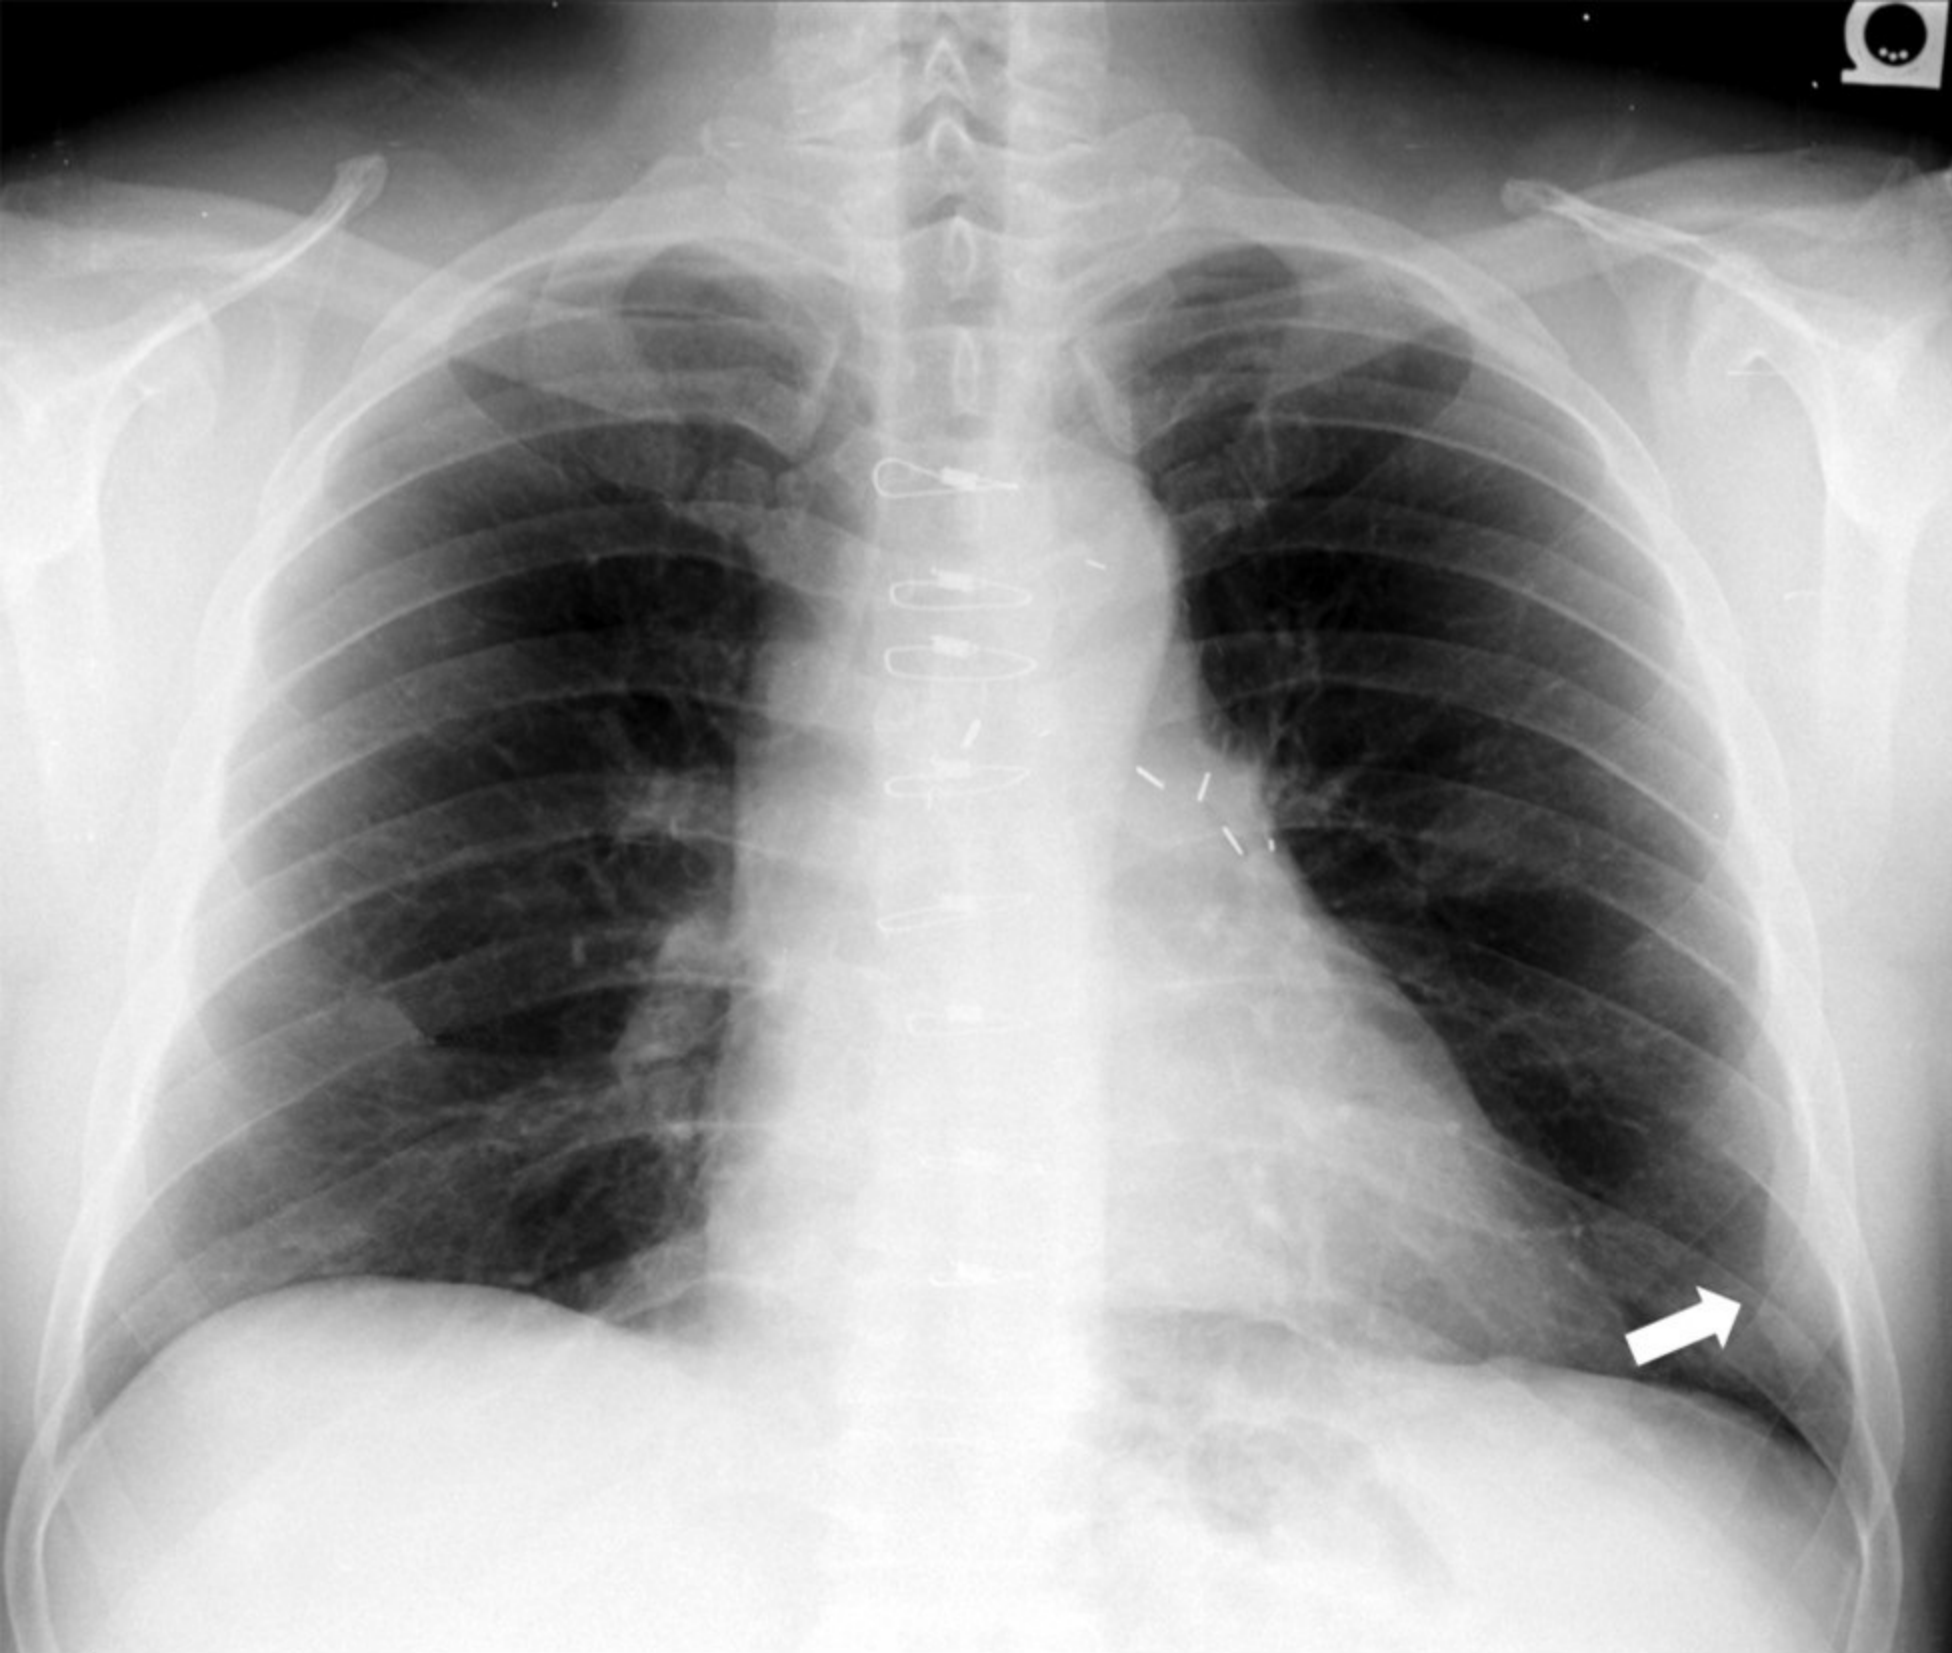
Demonstrates pleural thickening at the left base on chest radiograph (white arrow); CT image showing pleural plaque (black arrows) not visible on the chest radiograph, while apparent pleural plaque at the left base on chest radiograph is shown to represent subpleural fat (white arrow).
